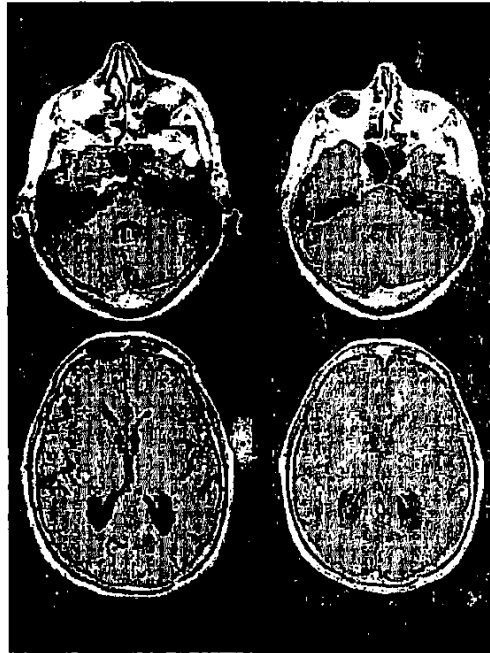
Contrast-enhanced brain Magnetic Resonance Imaging (MRI) before (*left*) and after (*right*) two cycles of Temodar for brain metastases from Non-Small-Cell Lung Cancer (NSCLC). The lesions have disappeared.
